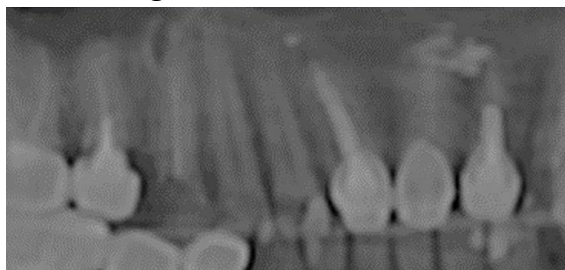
Diagnosis of periapical lesions
